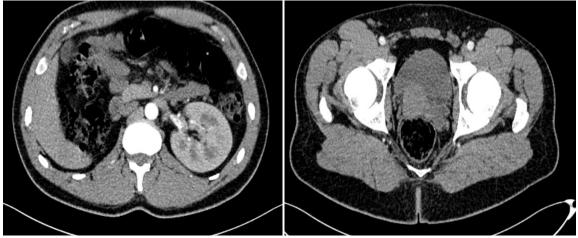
Contrast-enhanced CT scan (axial view) showing absent right kidney and a right seminal vesicle cyst adjacent to the bladder and rectum
